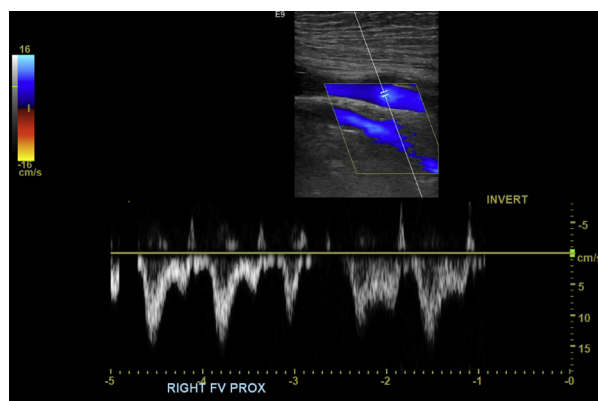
Ultrasound image of right proximal femoral vein (PFV) demonstrating lack of thrombus.
